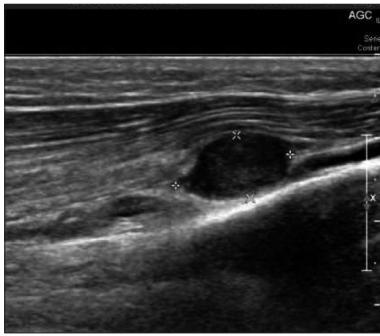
Ultrasonographic image of the right leg suggesting approximately 1.42×0.77×1.12 cm sized, probably benign peripheral nerve sheath tumor (PNST) arising from right deep peroneal nerve sensory branch.
